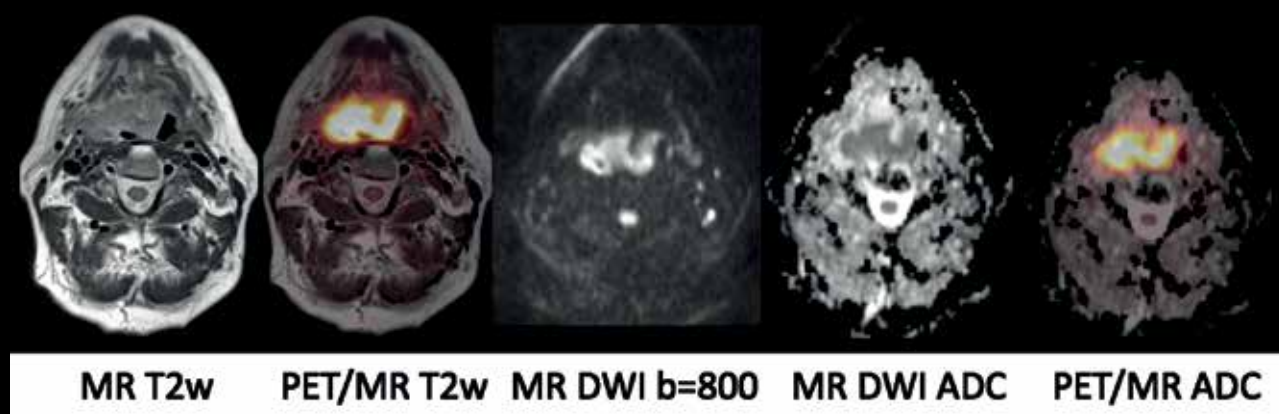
^{18}F -FDG PET/MR . 72-year old male with newly diagnosed squamous cell carcinoma involving the right tonsil and tongue base region. There is good agreement between the FDG-avid tumor and the diffusion weighted images.
